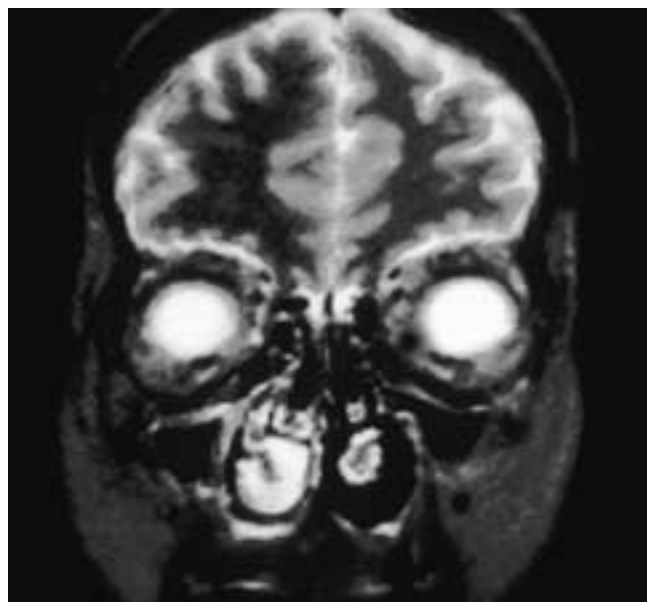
Coronal T2-weighted MR image shows swelling of the right inferior and middle turbinates, while the left turbinates have a shrunken appearance. In addition, there is some mucosal thickening in the right maxillary and ethmoid sinuses. This is an example of the normal nasal cycle in a symptomatic patient.
